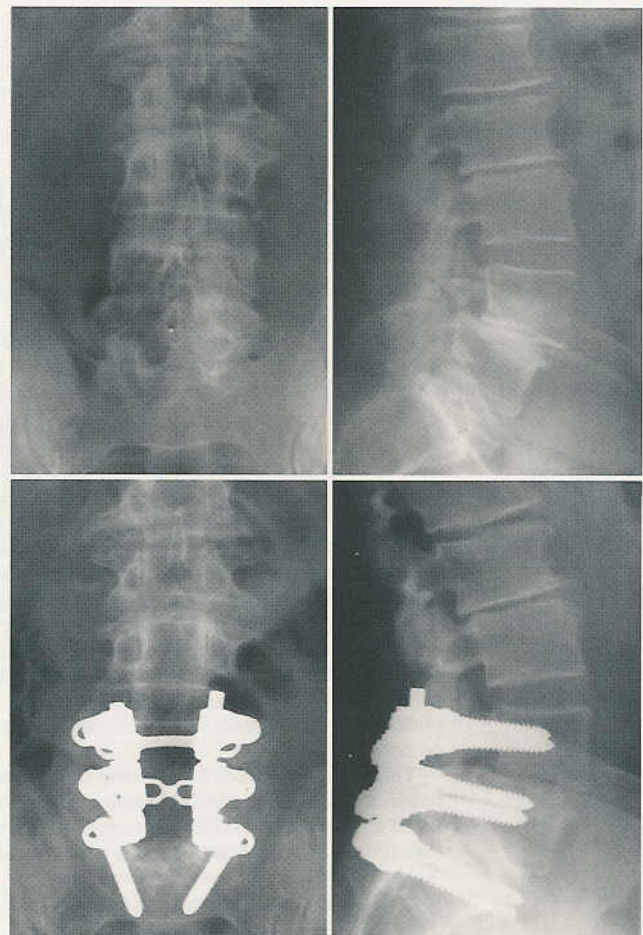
Radiographs obtained in a 53-year-old man with Grade I spondylolisthesis and pars defect who had undergone a previous hemilaminectomy. *Upper Left and Right:* Preoperative views. *Lower Left and Right:* Postoperative views demonstrating decompression, solid posterolateral fusion, and transpedicular screw fixation.
